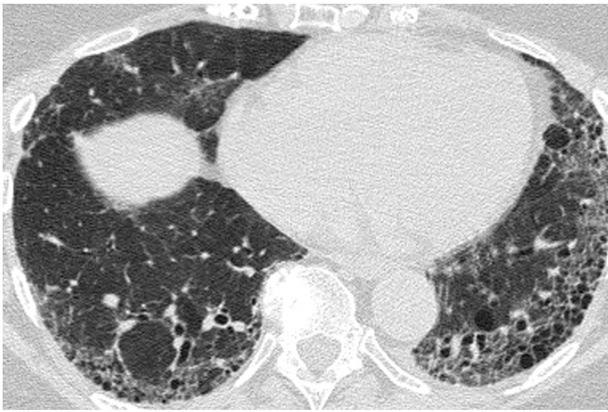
UIP pattern on HRCT: Subpleural basilar predominant fibrosis with honeycombing which is defined by Webb as “rounded lucencies with shared walls in vertical stacks that are sub-pleural and occur in association with other findings of fibrosis”.
